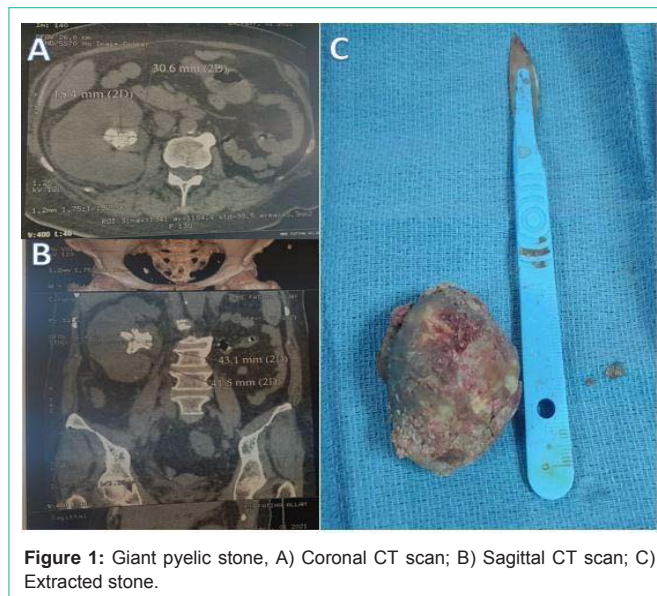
Giant pyelic stone, A) Coronal CT scan; B) Sagittal CT scan; C) Extracted stone.
